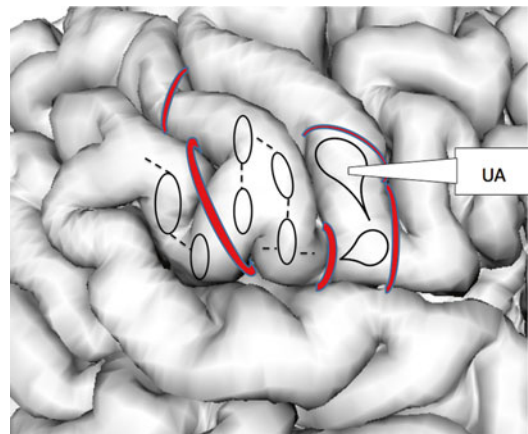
Lower central area and anterior limb of supramarginal gyrus resection, an example of endopial intervascular emptying. The ultrasonic aspirator (UA) is the ideal tool used at low settings of aspiration and amplitude. Small openings are made in the pia over the gyrus surface in order to introduce the suction tip to start the subpial and endopial removal of tissue. The pial openings are enlarged by coagulating and dividing the pia with microscissors (*dashed lines*) while preserving bypassing vessels and adjacent sulci. The pial layers of the sulci, overlying cisterns and Sylvian fissure, in this case, are all kept intact. Ultimately, the desired gyrus or gyri are emptied in a subpial fashion in order to treat the condition as well as preserve function
